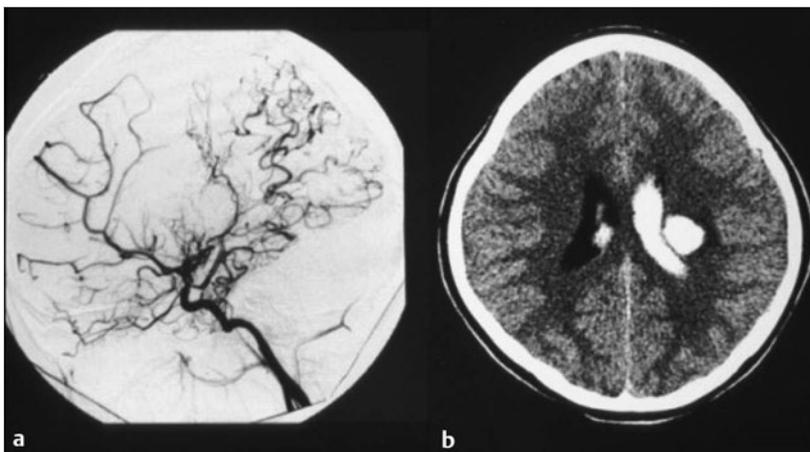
Moyamoya disease. (a) Lateral cerebral angiogram showing stenosis of the posterior circulation with recruitment of extracranial arterial supply to the parietal and occipital lobes. (b) In same patient, computed tomography scan showing left parenchymal and intraventricular hemorrhage as a result of moyamoya disease.
